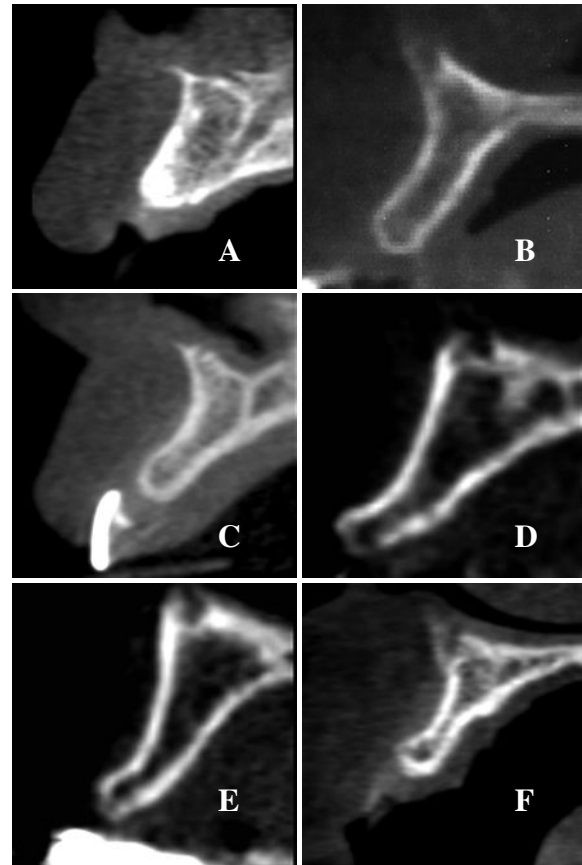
CBCT images of increasing degrees of horizontal bone loss, labial undercut, reduced marrow volume and cortical bone margin thickness. A. Mild horizontal dimensional loss after grafting for site preservation, B. Mild horizontal loss with minimal undercut and good marrow-cortical bone anatomy, C. Mild horizontal bone loss with increasing undercut and reduced marrow space, D. Moderate horizontal bone loss with moderate undercut and reduced marrow space, E. Moderate to severe horizontal bone loss with moderate undercut and reduced marrow space, F. Severe horizontal bone loss with severe undercut and reduced marrow space with thick “bi-cortical” bone.
